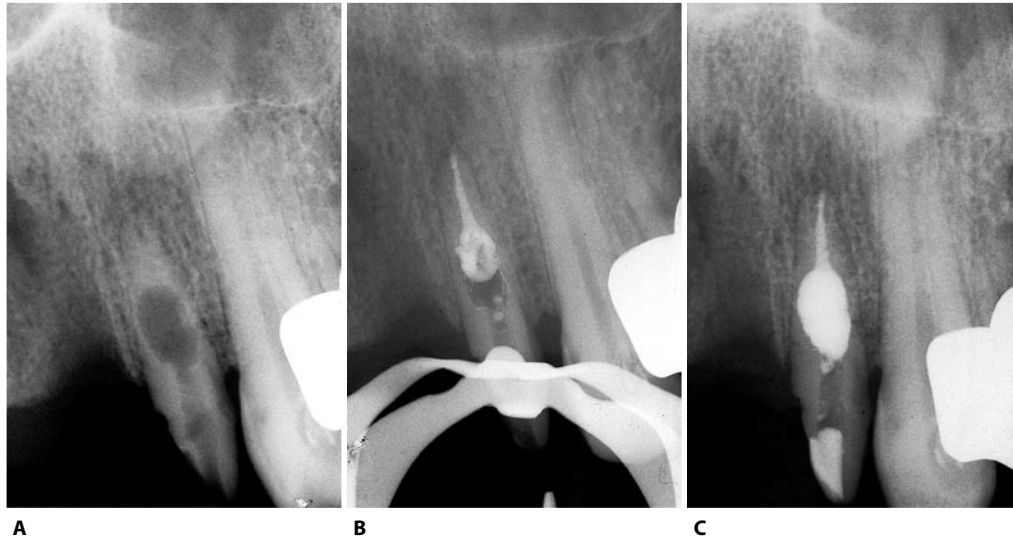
A. Preoperative radiograph of an upper left lateral incisor with considerable internal resorption. Once the resorption is diagnosed, it is always necessary to intervene quickly because the lesion could progress. B. Intraoperative radiograph of the apical condensation. C. Postoperative radiograph. The area of internal resorption has been filled with thermoplastic gutta-percha.
